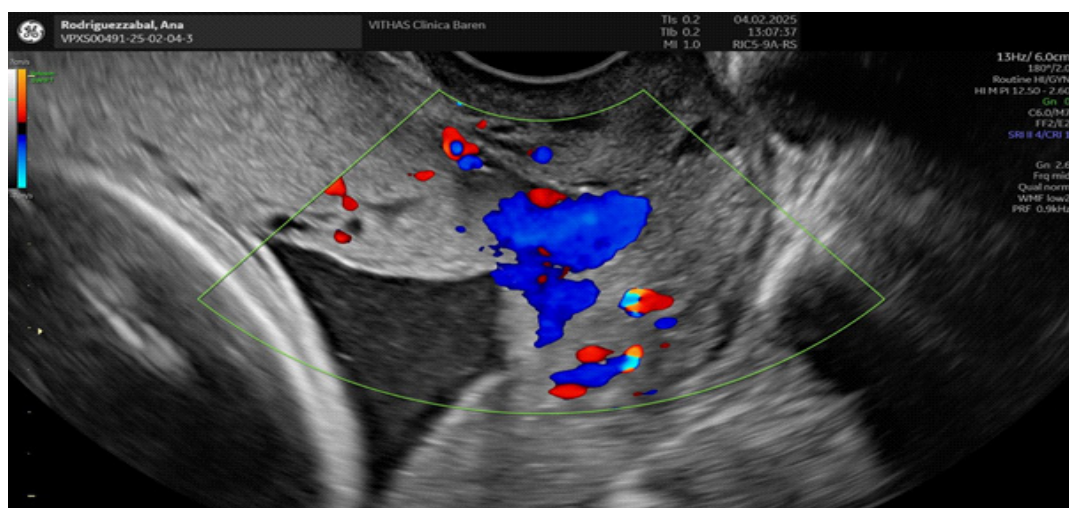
Vascular-like structure in front of the internal cervical os, showing umbilical flow in Doppler study.
